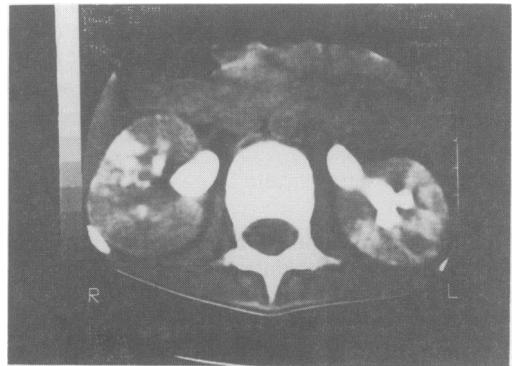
Contrast-enhanced CT scan of the kidneys showing bilaterally enlarged kidneys with abnormal contrast distribution consistent with areas of infarction.
